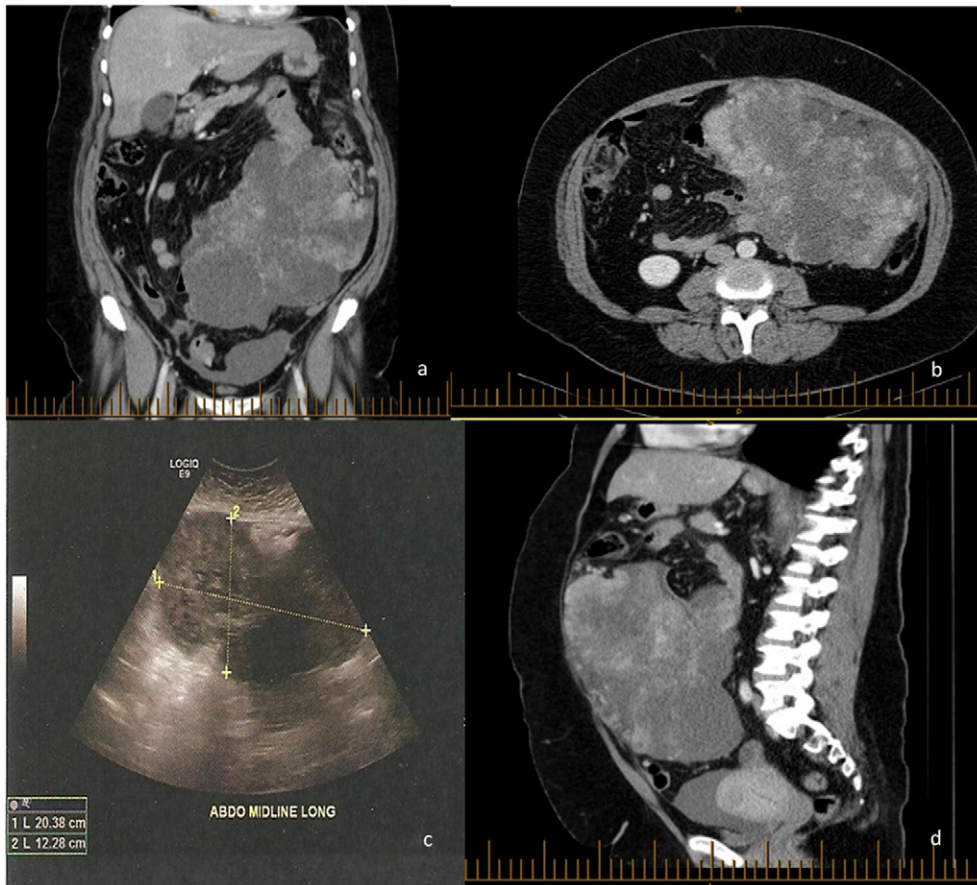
Computerized Tomography (CT) imaging of leiomyosarcoma (a, b, d) and ultra sound (US) scan (c) of primary leiomyosarcoma of the omentum.
